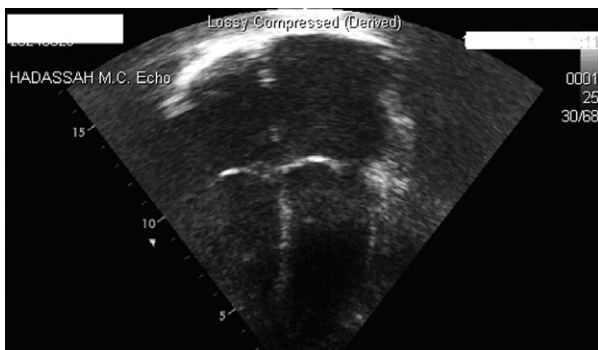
Echocardiogram in the same patient demonstrated moderately reduced LV function with dyskinesia of the mid- and apical anterior and septal wall, consistent with LAD territory. The mitral leaflet is thickened and the anterior leaflet is prolapsing, resulting in moderate posterior jet regurgitation. An apical aneurysm can be seen on the echo presented.
